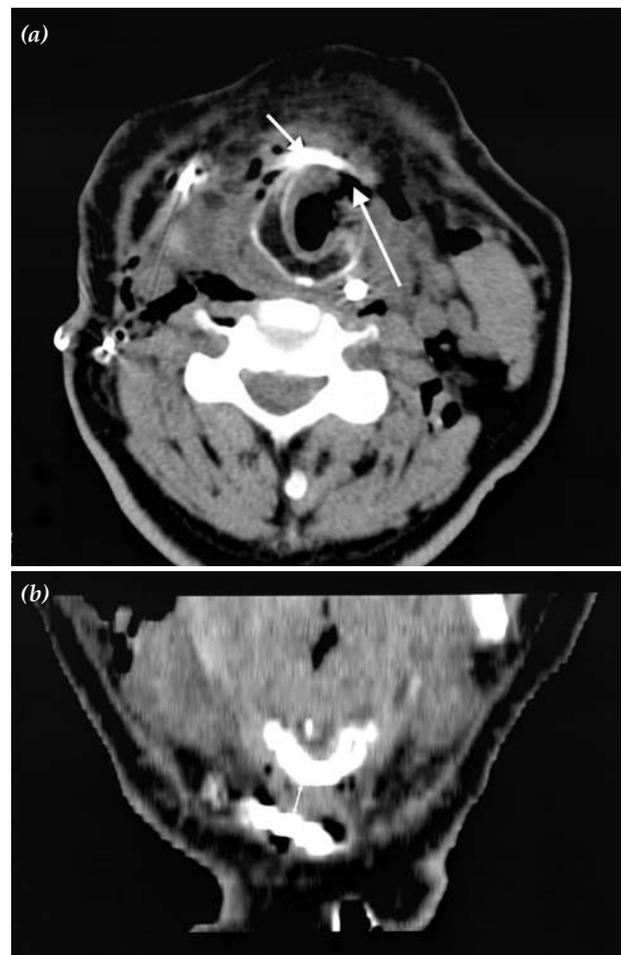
(a) Postoperative axial computed tomography view showing the cricothyroid junction (short arrow) and air leakage from the pexy line (long arrow). (b) Coronal reconstructed image shows that the distance between the cricoid and hyoid is less than 10 mm (arrow).
